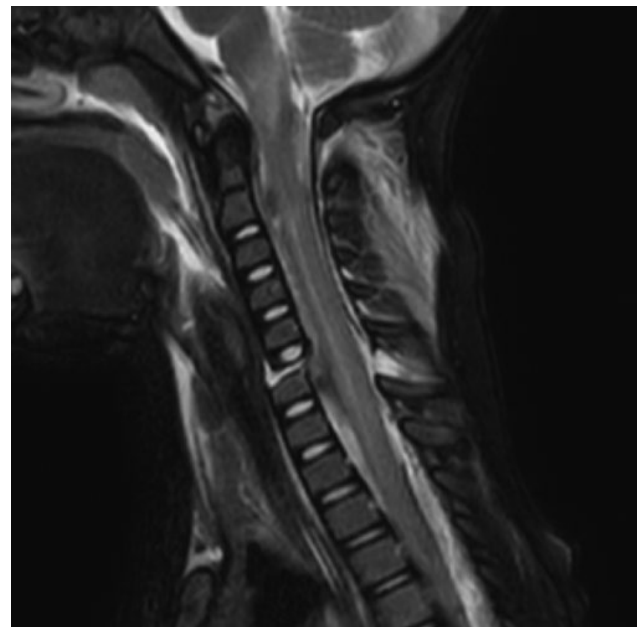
MRI of cervical spine demonstrates a large extradural hematoma. Sagittal T2 fat-saturated image of the cervical spine again demonstrating oblique, comminuted C6 vertebral body synchondroses fractures with mild distraction and retrolisthesis of the superior fracture fragment. Disruption of the anterior and posterior longitudinal ligaments and interspinous ligament. Epidural hemorrhage is present with subsequent mass effect on the cord. Diffusely increased signal of the cord consistent with long segment cord injury from the medulla oblongata down to the level of C7.
